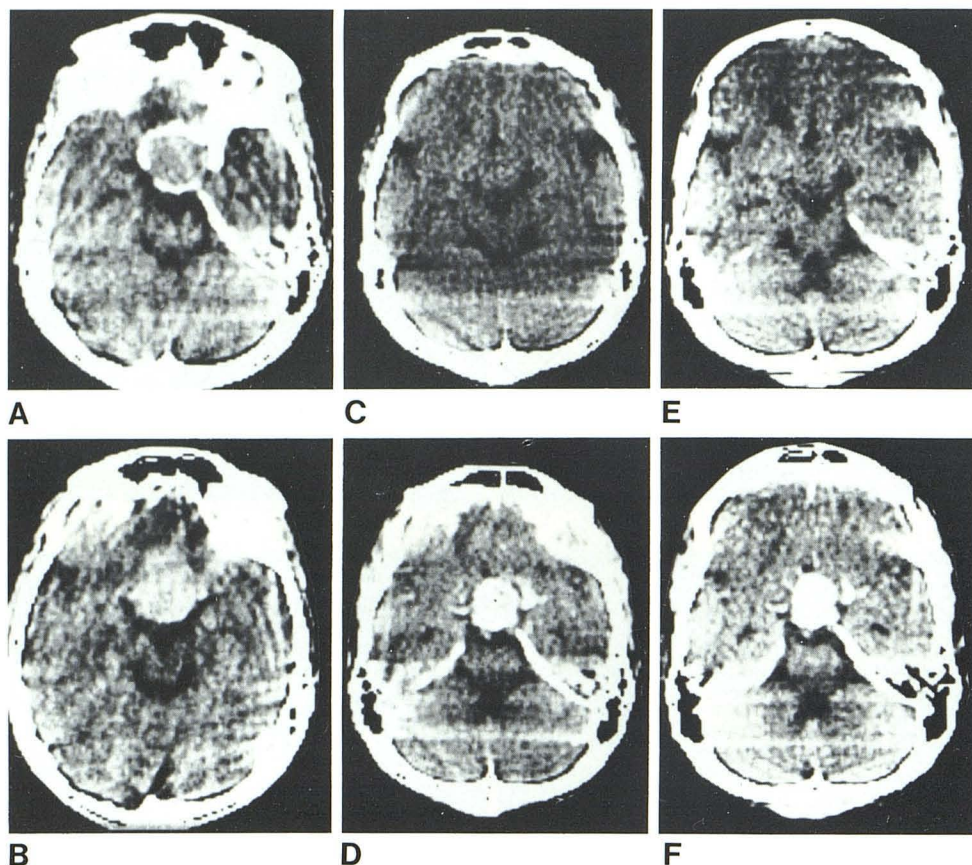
A and B, First CT scans in 37-year-old man were obtained only after contrast enhancement. Markedly expanded sella containing dense lesion with suprasellar extension. At surgery, mass proved to be nonfunctioning adenoma. Pre- (C) and post- (D) enhancement scans 1 year after transsphenoidal hypophysectomy and subsequent radiation therapy. Persistent though smaller enhancing lesion with suprasellar extension. Pre- (E) and post- (F) enhancement scans almost 2 years after surgery. No change in size or degree of enhancement of residual lesion. Patient remained asymptomatic.
